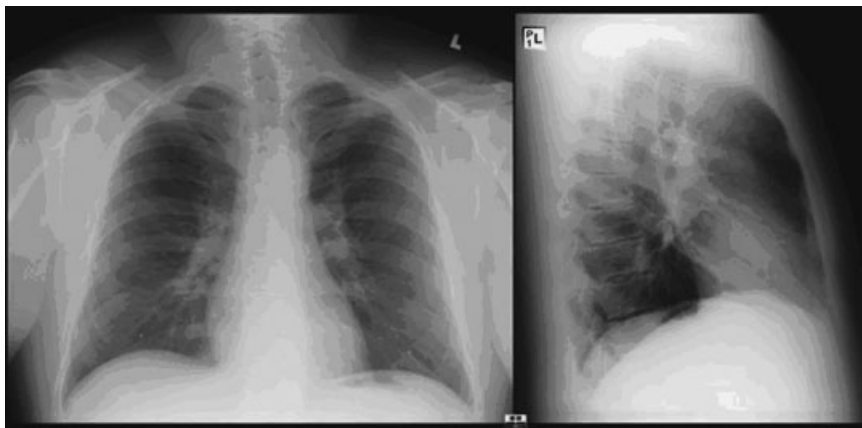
Stage 0 radiographic sarcoidosis. This normal chest x-ray may be observed in 5 to 15% of cases.
